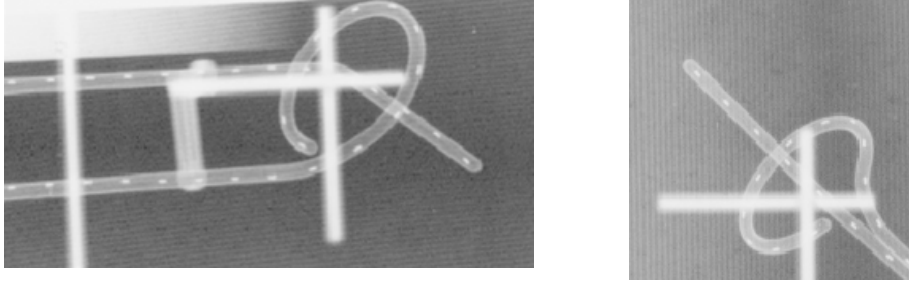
Orthogonal X-ray films for digitization. Geometry for the 60° ring and 40 mm probe. To the left lateral image and to the right AP.
